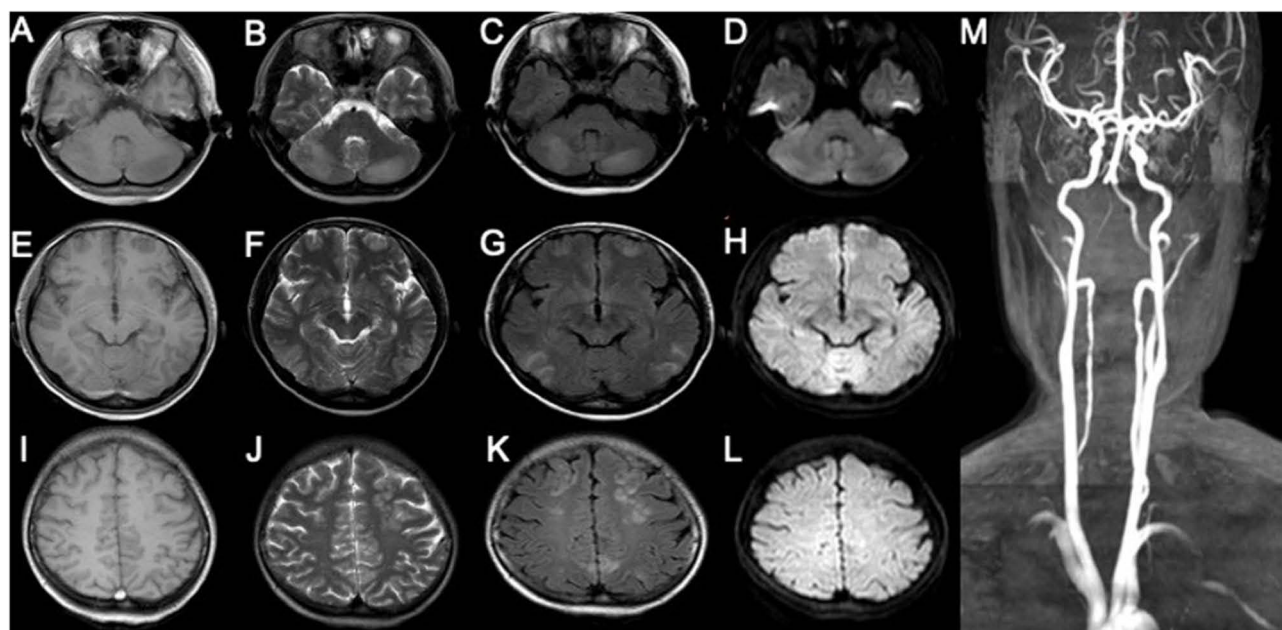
MRI and MRA findings obtained on the 2nd day. Symmetric lesions in the frontal, parietal, and occipital lobes and cerebellar hemispheres showed hypointense on T1-weighted images (A, E and I), hyperintense on T2-weighted images (B, F and J) and FLAIR images (C, G and K), isointense or slight hypointense (D, H and L), on DWI. The distal portion of right vertebral artery was visualized ambiguously, and the left vertebral artery presented one aneurysmal dilation (M).
